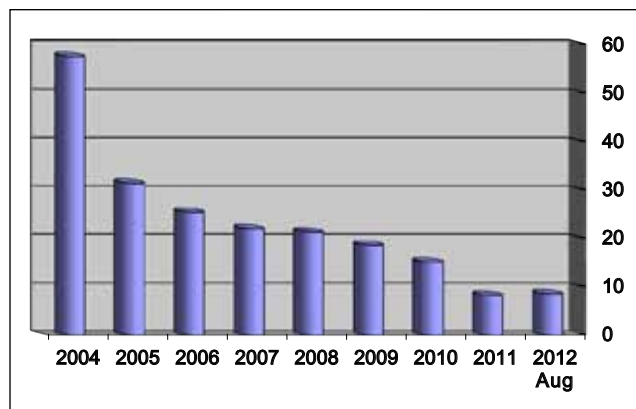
Mean X-ray time (min).
